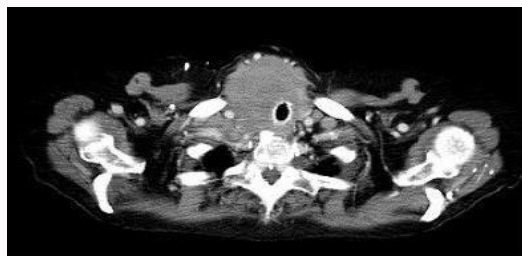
CT-scan after insertion of tracheal stent.
